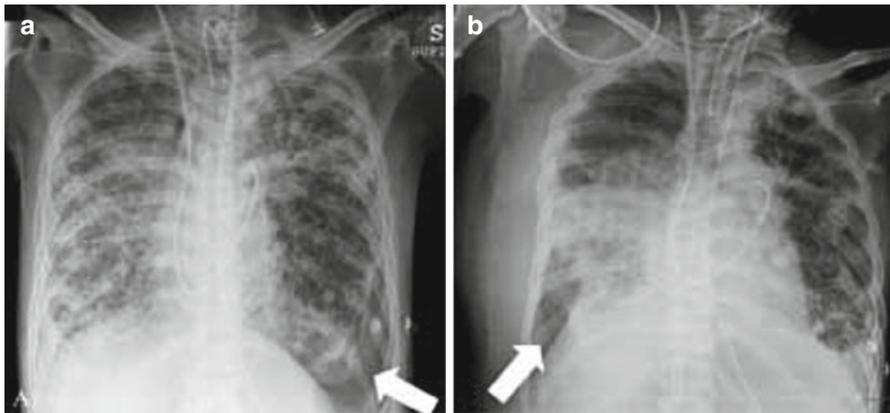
Bilateral pneumothorax in a patient with severe pulmonary tuberculosis. Chest x-rays showing left (panel a) and right (panel b) spontaneous pneumothorax. Both were left undrained and ventilation pressures were decreased while oxygenation was guaranteed by extracorporeal membrane oxygenation (ECMO). The patient eventually survived. *Arrows* indicate air presence in the pleural spaces (Reprinted by permission of Edizioni Minerva Medica from Mauri et al. [24])
